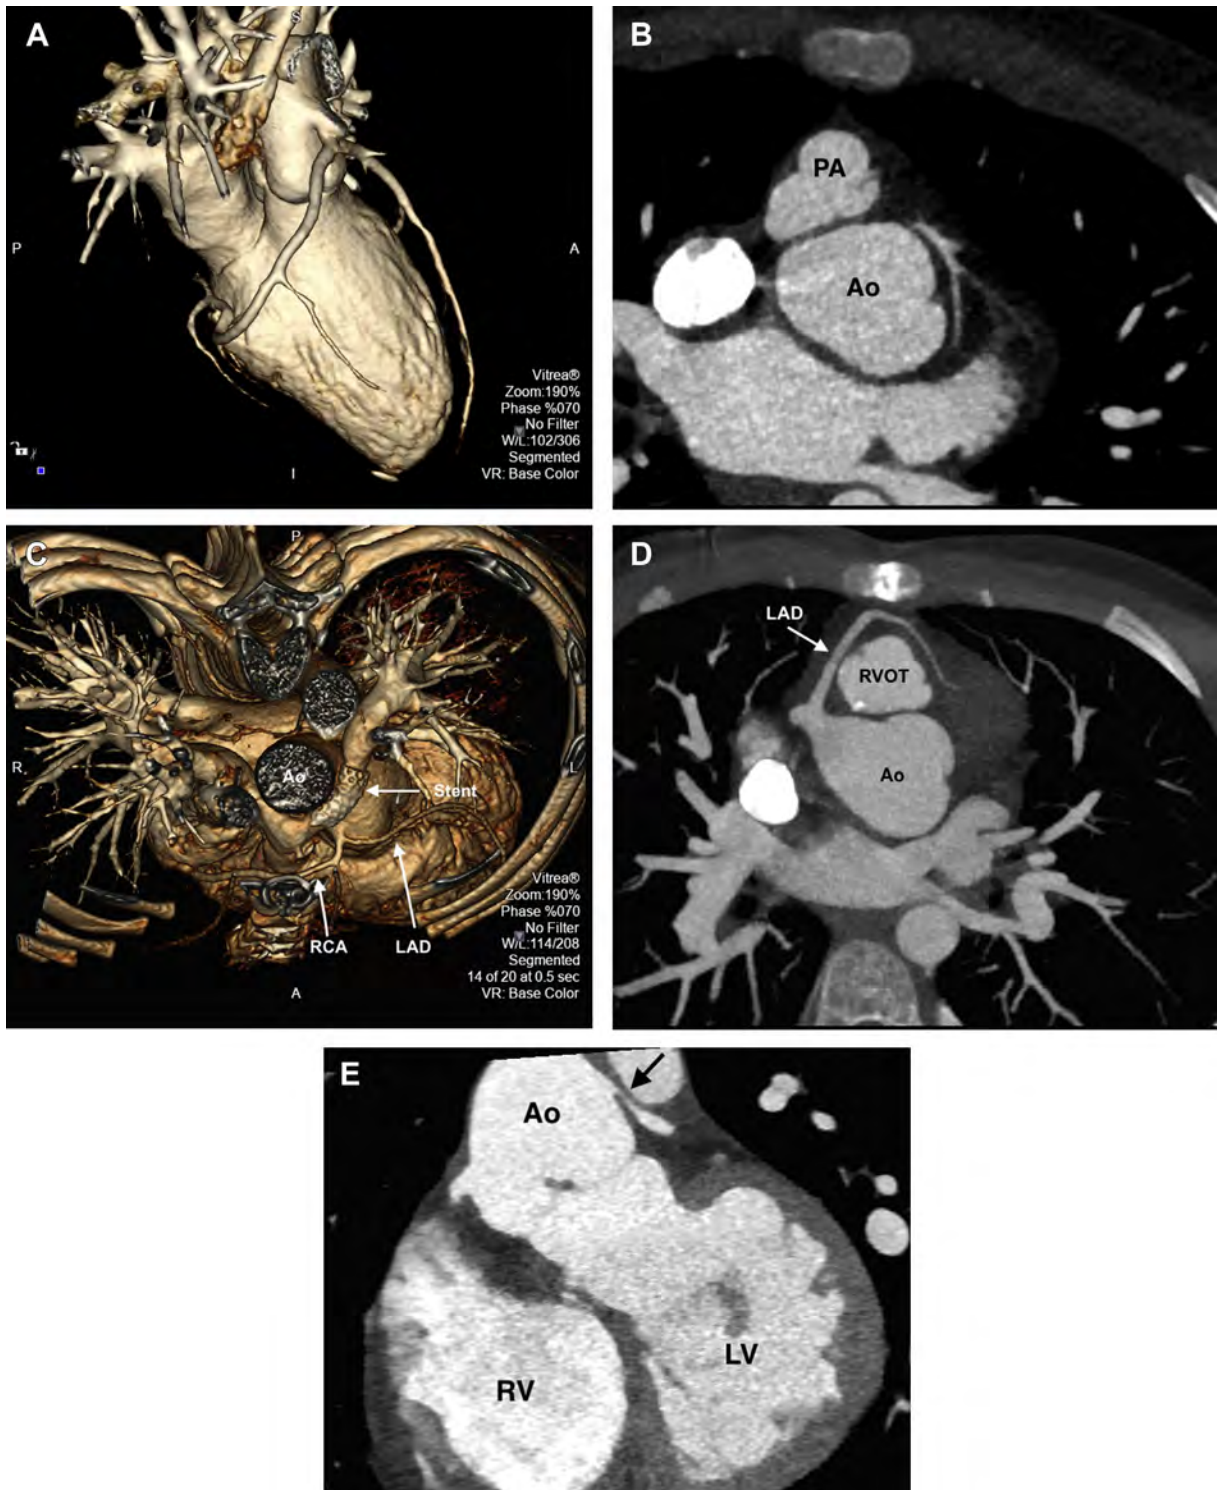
Computed tomographic images of the CAs after the ASO. (A) A 3D reconstruction demonstrates a single CA arising anteriorly after reimplantation. The pulmonary artery is cut away from the image. (B) A 2D image shows severe left main CA stenosis after the ASO. Note the neopulmonary root (PA) anterior to the neo-aortic root (Ao). (C) A 3D reconstruction after the ASO. Note the stent in the left pulmonary artery, and the subcostal right CA (RCA) coursing anterior to the right ventricular outflow tract with a common origin with the left anterior descending CA (LAD). (D) Two-dimensional image demonstrates a subcostal left anterior descending CA arising from the right coronary cusp of the neo-aortic root, coursing directly anterior to the reconstructed right ventricular outflow tract (RVOT). (E) Two-dimensional image shows a dilated neo-aortic root (Ao) with left main CA narrowing (*black arrow*) directly rightward of the right ventricular outflow tract. LV, Left ventricle; RV, right ventricle.
